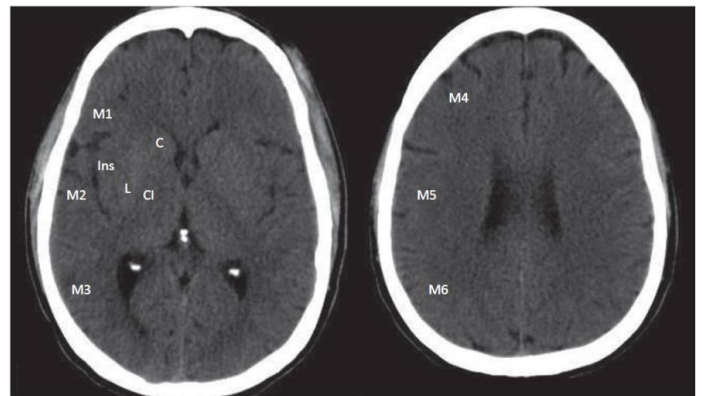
Areas assessed in the Alberta Stroke Program Early CT Score (ASPECTS). Six cortical areas (M1, M2, M3, M4, M5 and M6), insula (I), caudate (C), lenticular (L) and internal capsule (CL).
